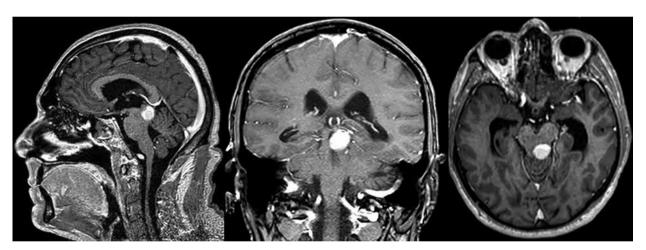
Magnetic resonance imaging of the brain with intravenous contrast before surgery: cavernous angioma of the brainstem in the area of the cerebral aqueduct
